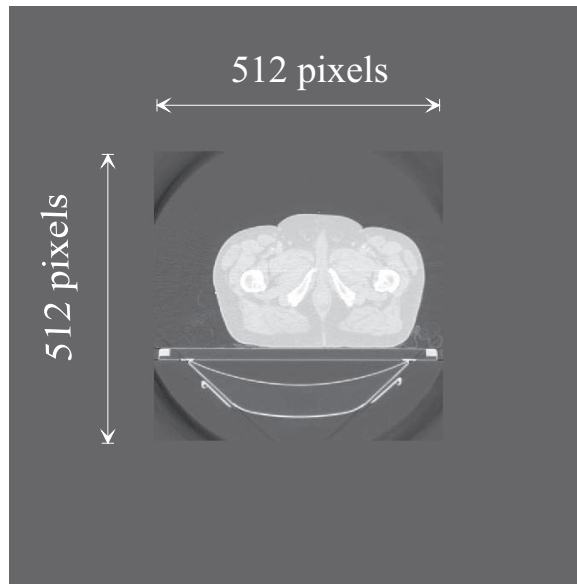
An expanded axial CT slice ($1024 \text{ pixel} \times 1024 \text{ pixel}$) of a prostate radiotherapy patient.
